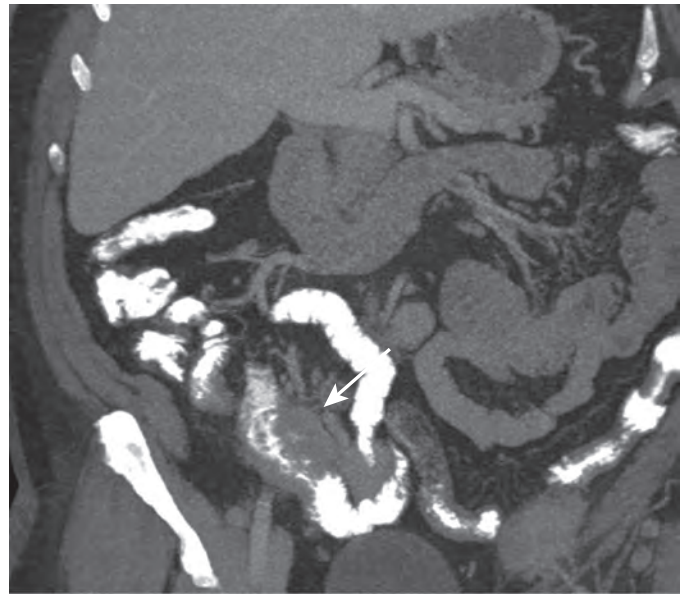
Behçet's disease. Coronal contrast-enhanced CT demonstrates marked thickening of the distal ileum (arrow), somewhat masslike in appearance. This was originally thought that it might represent lymphoma, but was found to be manifestation of Behçet's disease.
